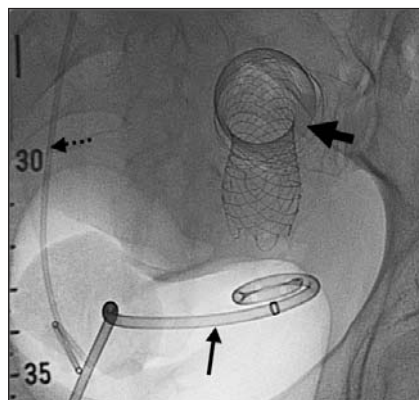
Radiograph showing the catheter inserted percutaneously to drain the pelvic abscess (arrow), the right ureteric stent (dotted arrow) and the self-expandable metallic colonic stent (fat arrow) within the sigmoid colon.
